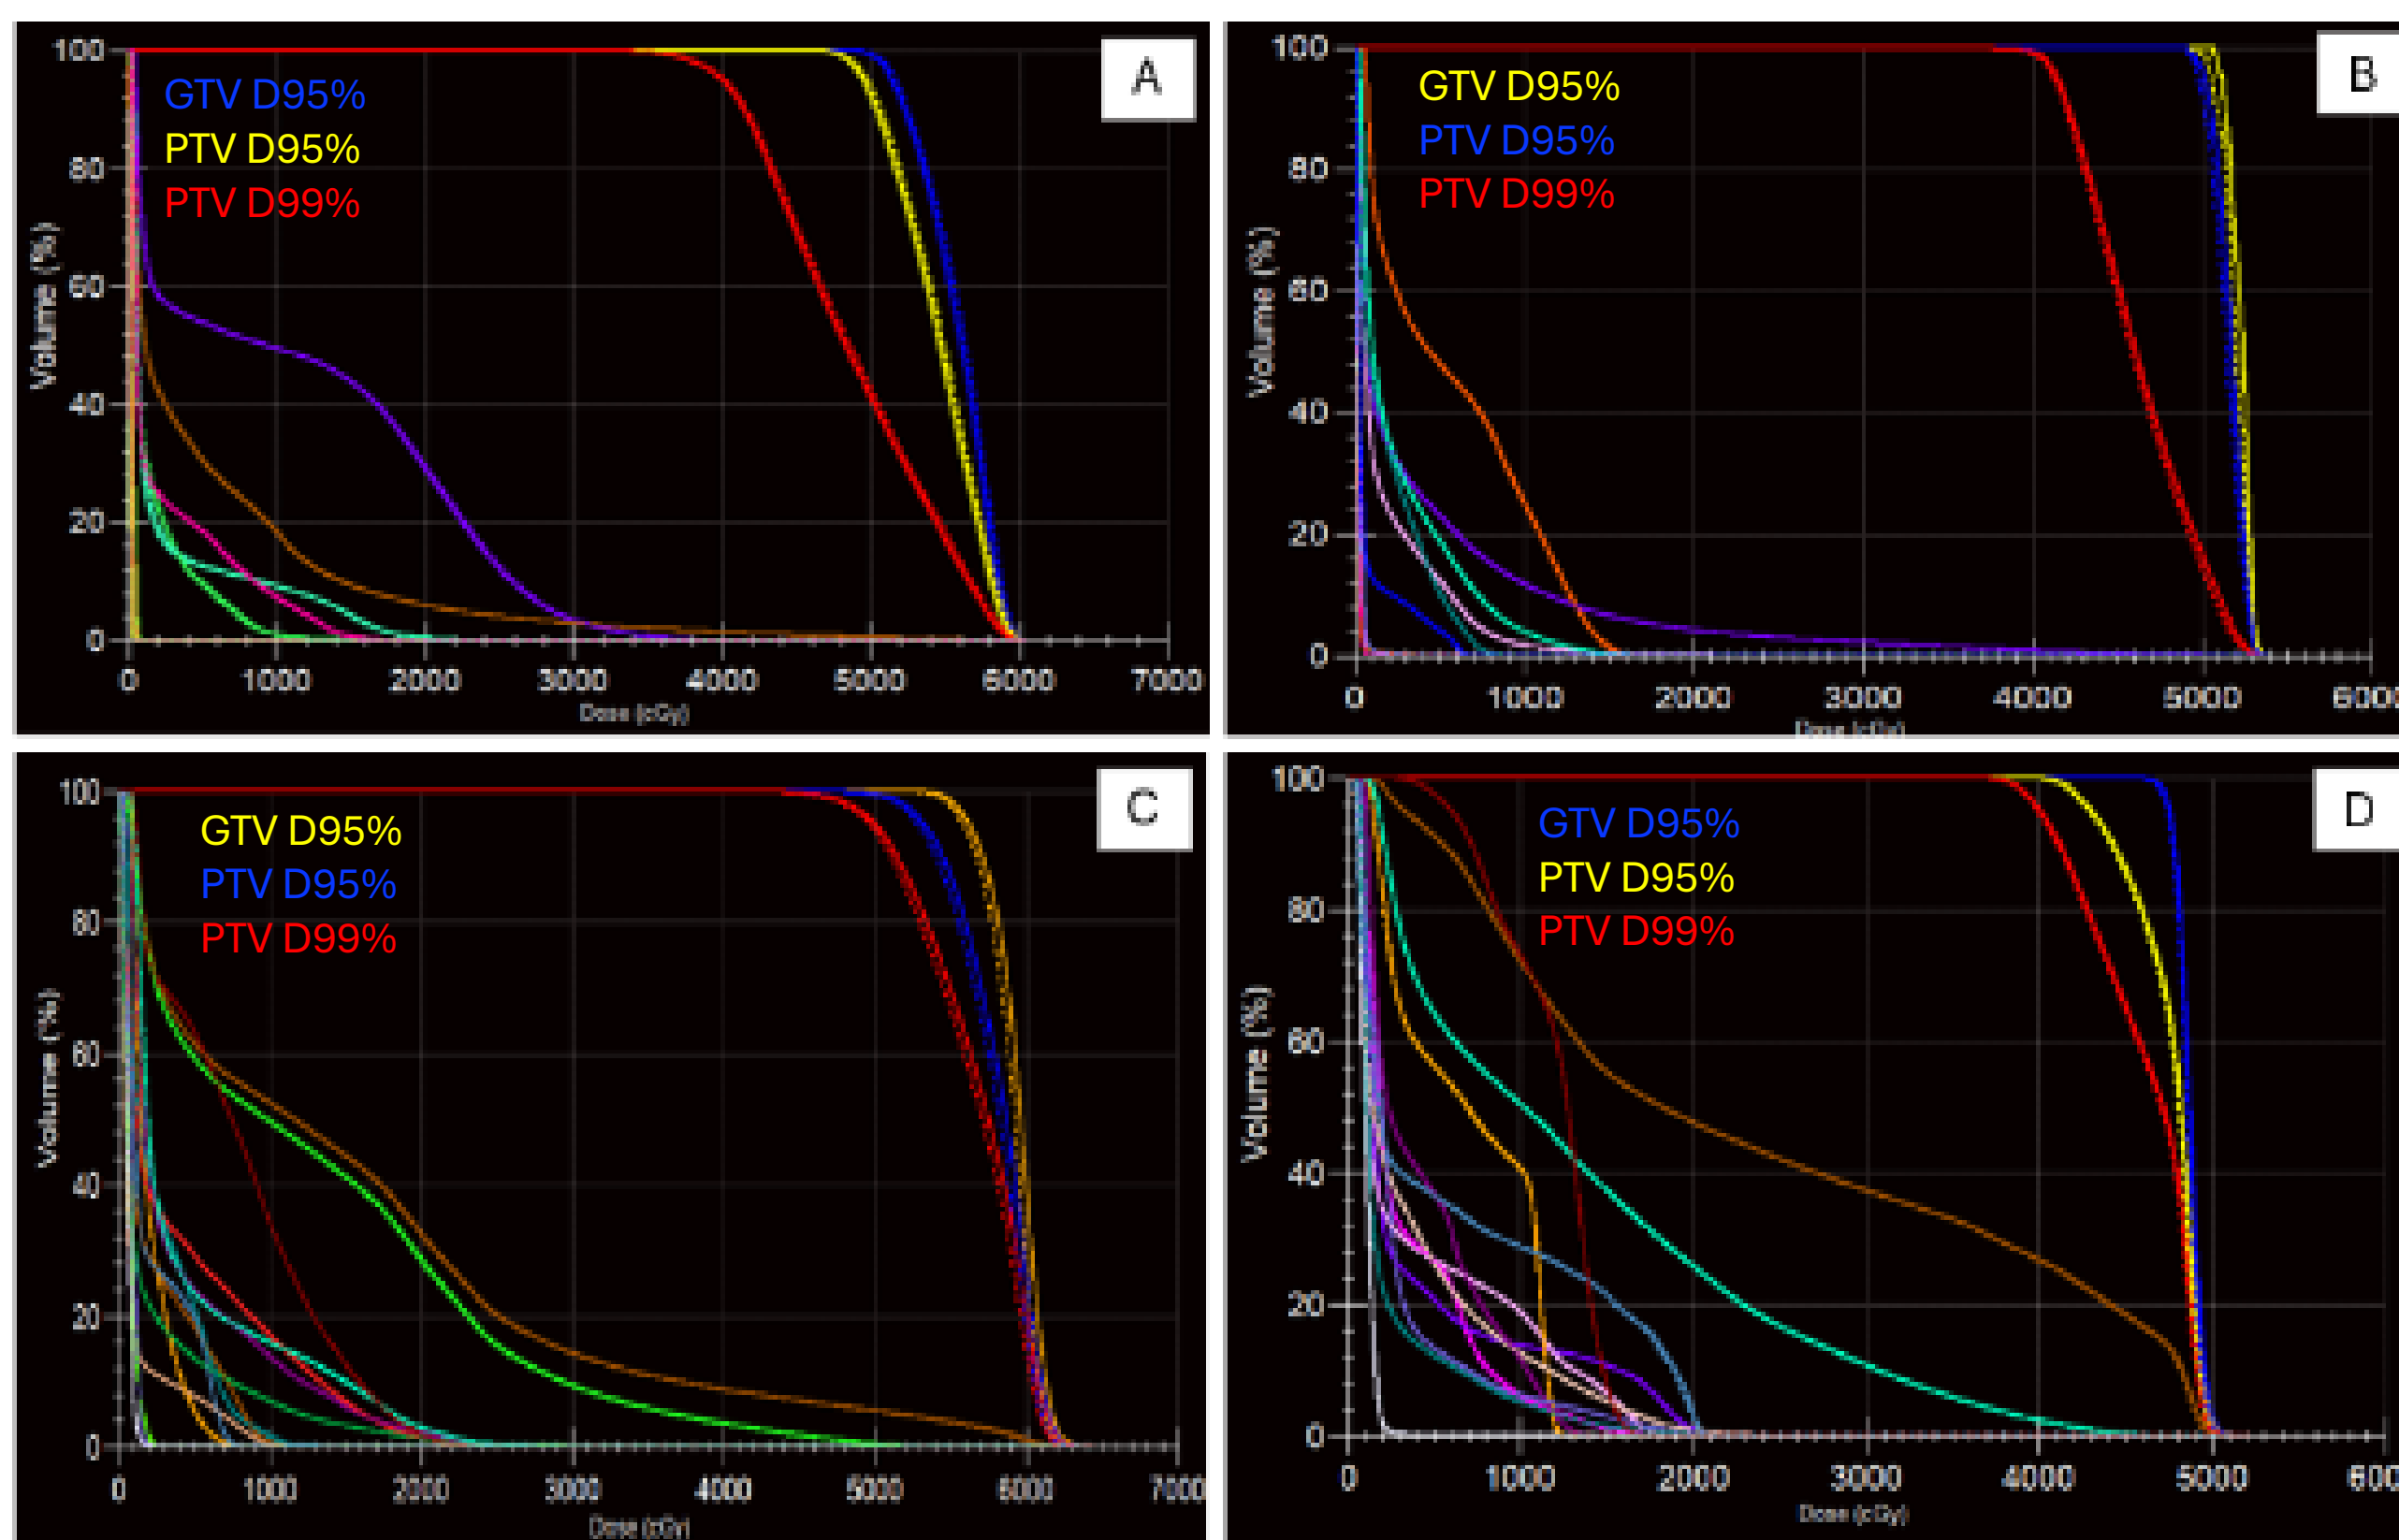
(a-d): Total Volume DVH comparisons of four liver lesion SBRT treatment plans using CT derived (solid) and tabulated (dashed) ED values. A) 57 y/o female 50 Gy / 5 fxns; B) 58 y/o male 40 Gy / 5 fxns; C) 71 y/o female 50 Gy / 5 fxns; D) 75 y/o male 20 Gy / 5 fxns.
